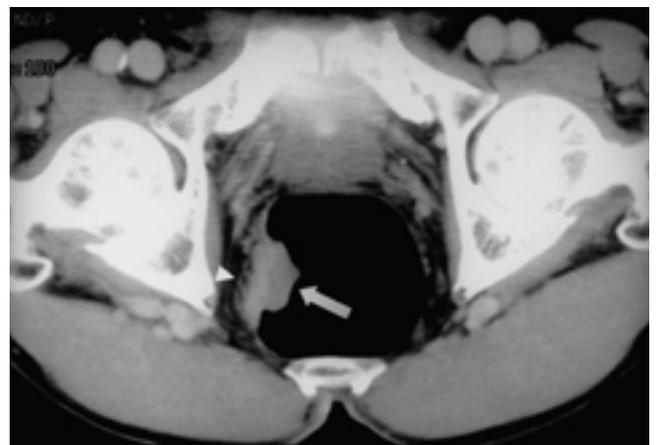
Postcontrast air insufflation helical CT shows fungating mass (arrow) of right lateral wall of rectum and linear strands (arrow head) into perirectal fat plane. Pathologic examination revealed tumor invasion into perirectal fat.
